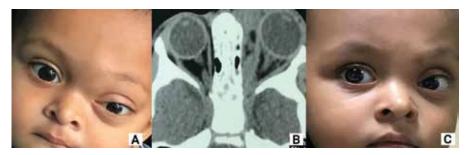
Veno – lymphatic malformation (Lymphangioma): A) Pre- treatment presentation as proptosis and periocular swelling, B) CT Scan showing multiple microcyst, C) Post treatment picture with intralesional Inj. Bleomycin.
